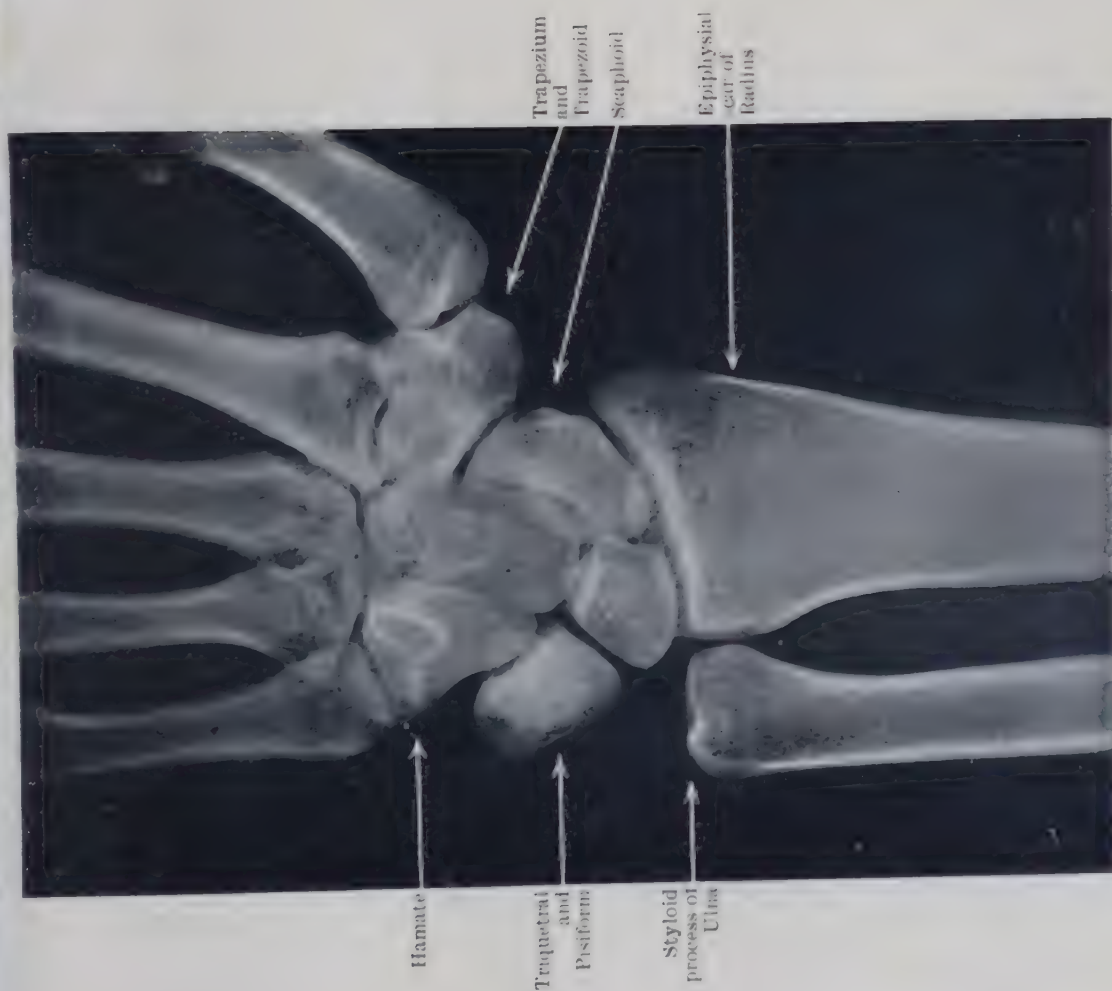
RADIOGRAPH OF WRIST SHOWING THE RELATION OF THE CARPUS TO THE RADIUS AND ULNA IN EXTREME RADIAL FLEXION (ADDUCTION) AT THE RADIO-CARPAL JOINT.
